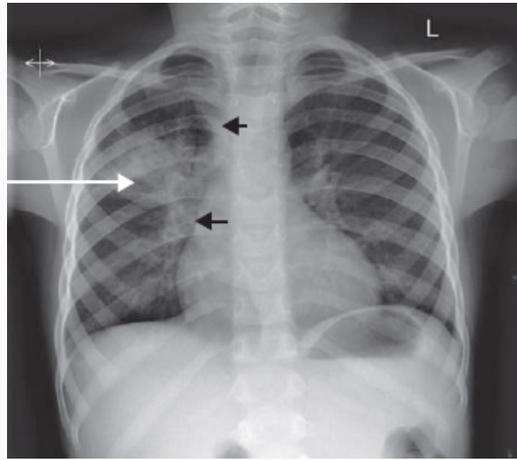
Chest radiograph showing right upper lobe pneumonia due to tuberculosis (white arrow), with enlarged lymph nodes (black arrows).
